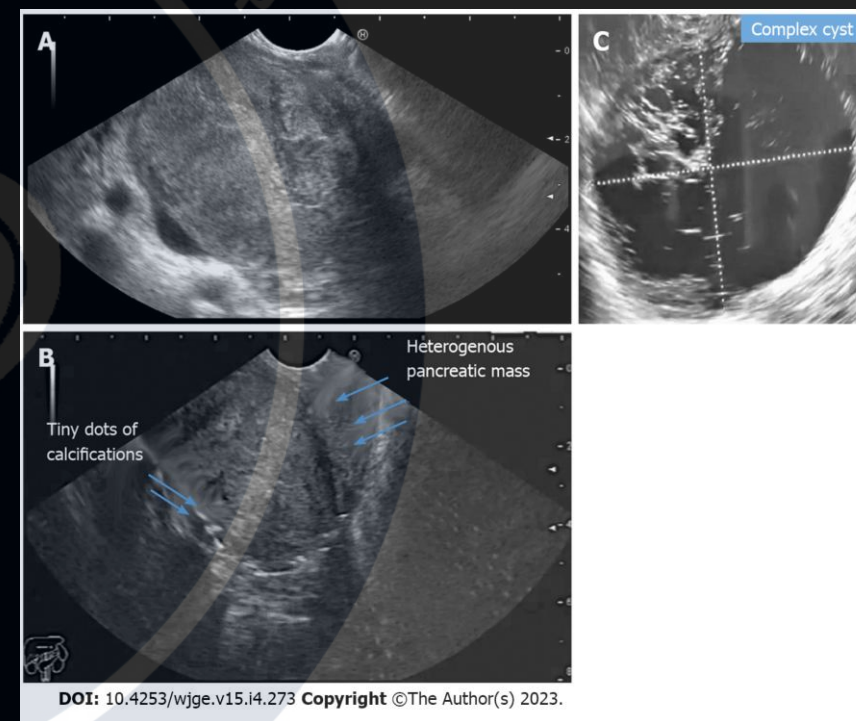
Endoscopic ultrasound. A: A large heterogeneous solid pseudopapillary neoplasm in the pancreatic head; B: A large heterogeneous solid pseudopapillary neoplasm with calcific spots in the pancreatic head; C: A cystic solid pseudopapillary neoplasm in the pancreatic body.
